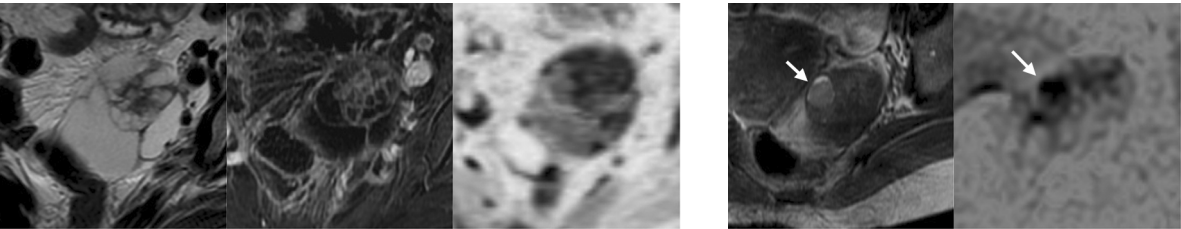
Mucinous CAF: Multilocular cystic mass containing “black sponge-like” solid portion on T2WI (a). Solid portion shows intense CE (b). Viscous or hemorrhagic contents in small loculi show high intensity on DWI. (c)
